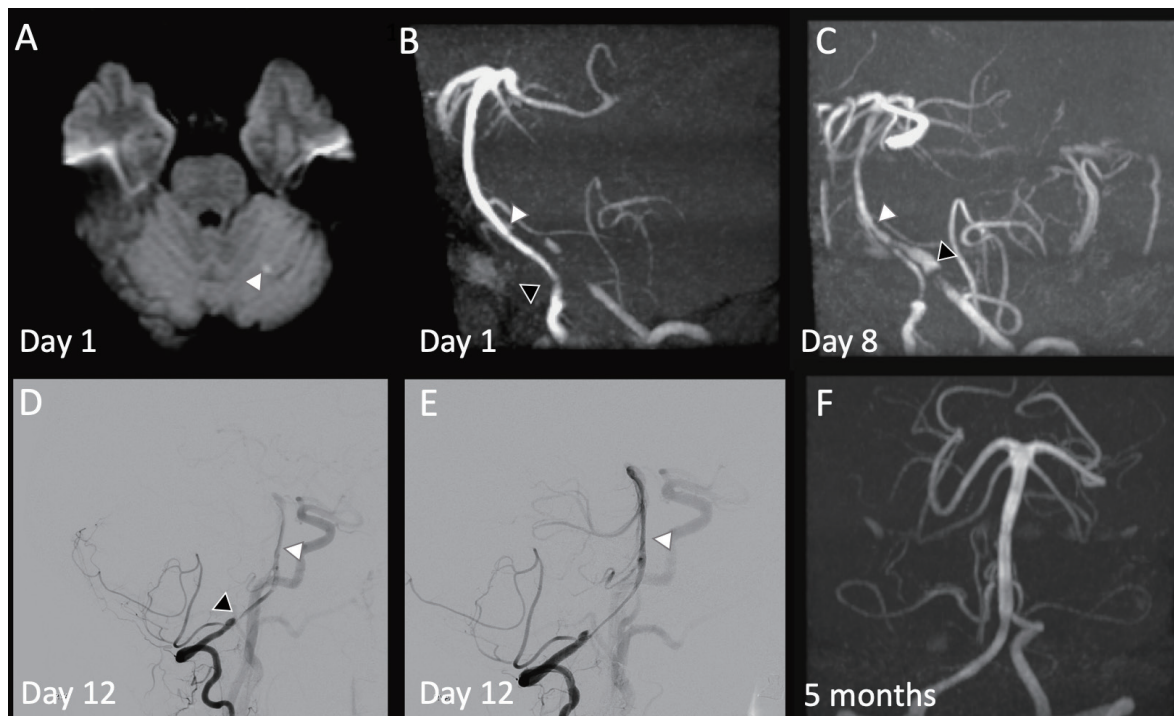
A: Diffusion-weighted imaging of the brain MRI showed a tiny acute infarct (arrowhead) at the left cerebellum. B: MRA of the brain showed short-segmental stenosis of the bilateral distal VA with proximal BA involvement (white arrowhead: VB junction; black arrowhead: dissecting stenosis of right VA). C: MRA of the brain showed progressive narrowing of the dissecting stenosis of the BA and aneurysmal formation of the left distal VA (white arrowhead: VB junction; black arrowhead: aneurysmal formation of the left distal VA). D: Digital subtraction angiography in oblique sagittal view showed trickle blood flow over the right distal VA and BA. (white arrowhead: BA; black arrowhead: right distal VA;)E: Post-stenting digital subtraction angiography in oblique sagittal view showed recanalization of the right distal VA to mid-BA with 60–70% residual stenosis. (arrowhead: restoration of BA flow after stent placement). F: Follow-up MRA of the brain 5 months after the endovascular intervention showed fair patency of vertebrobasilar system.
